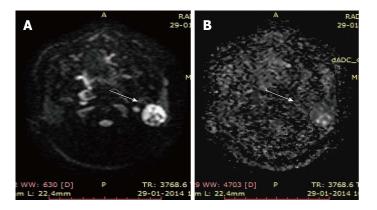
Axial diffusion weighted magnetic resonance imaging. (A) At b = 1000 s/mm² hyperintensity is noted throughout the mass (arrow) except the cystic areas. These regions were dark (arrow) on ADC map (B) consistent with restricted diffusion.
